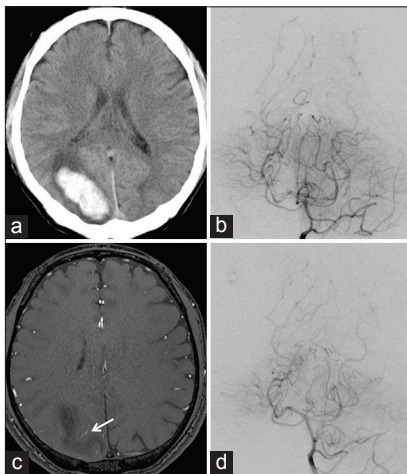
(a) CT scan at admission showing an intracerebral hemorrhage in the right parietal lobe. (b) A left internal carotid angiogram on admission showing no definitive vascular abnormality. (c) A time-of-flight MR image showing a small but abnormally dilated vein (arrow) near the hematoma. (d) A left internal carotid angiogram repeated in 2 weeks clearly showing the early draining vein (arrowhead) near the hematoma
